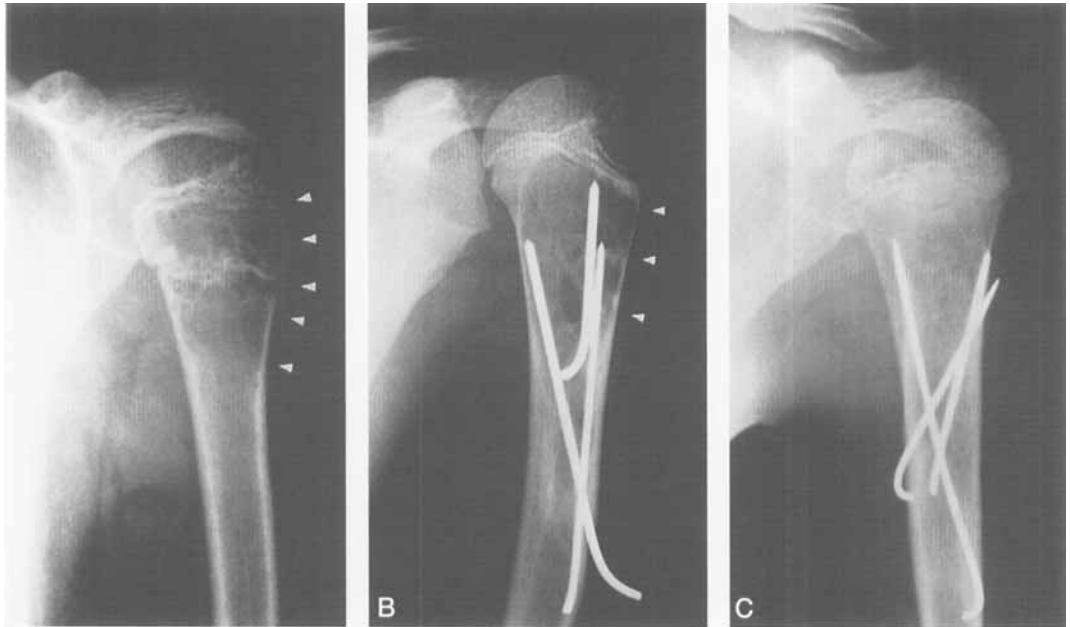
11-year-old boy. Cyst with pathological fracture in the proximal humerus (A). A second drill-hole operation was necessary after 25 months because of a residual cyst (B). The radiographs show good bone formation in the cyst 8 months after the second operation (C).
